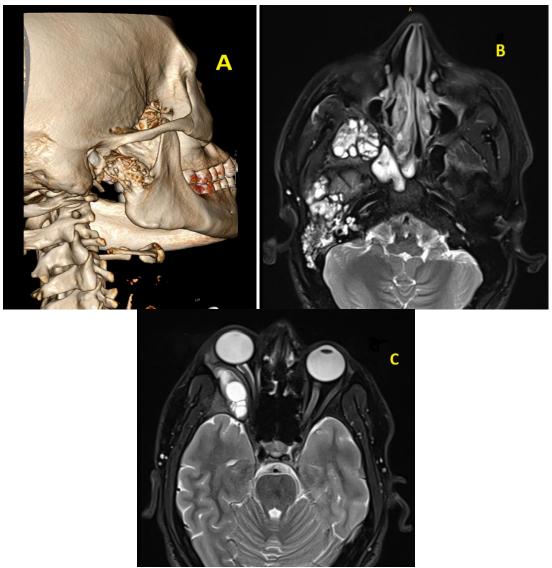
A) 3D-CT reconstruction showing massive cortical destruction of the right mandibular condyle and ramus. B) Axial T2 MRI image showing Multiloculated, hyperintense cystic mass with daughter cysts in mandibular condyle, ramus, and parotid/masticator space. C) Axial T2 MRI image showing Separate hyperintense cyst causing compression/proptosis in the right orbit.
